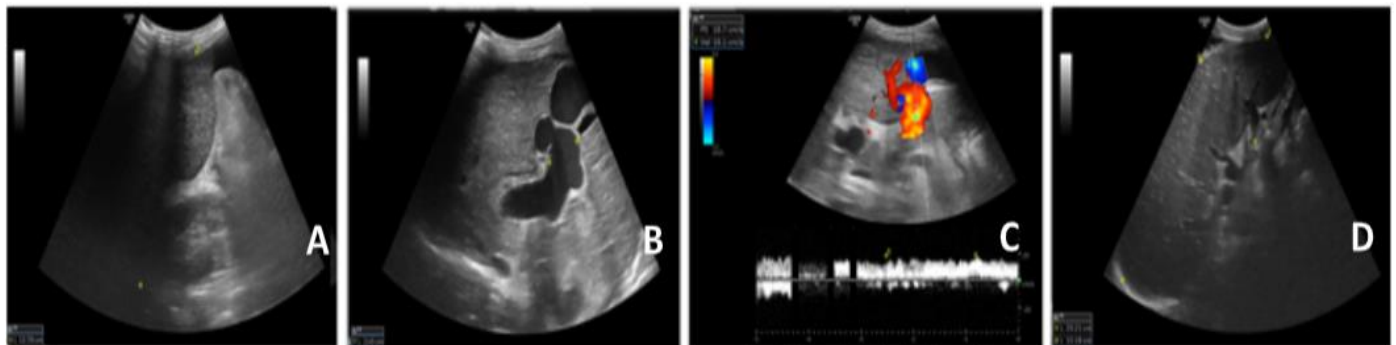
(A-D): A male patient 60 year old presented with grade IV EV post DAAS therapy with platelet count 63000 n/u.l. Abdominal ultrasonography reveals cirrhotic liver with liver span 12.39cm (A), PV diameter 24.5mm (B), PVV 18.1cm/sec (C), longitudinal and transverse splenic diameters 29.21cm and 10.18cm. $SI=29.21 \times 10.18=297.35$, $SPI=297.35/18.1=16.42$, $PCSDR = 63000/292.1=215.67$
